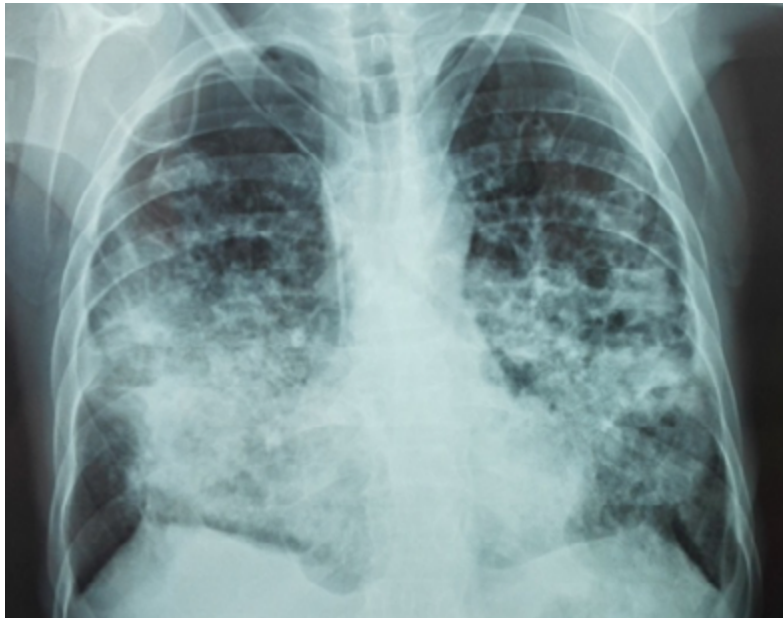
Chest x-ray with abundant alveolar opacities in both lung fields with formation of pneumatoceles.
